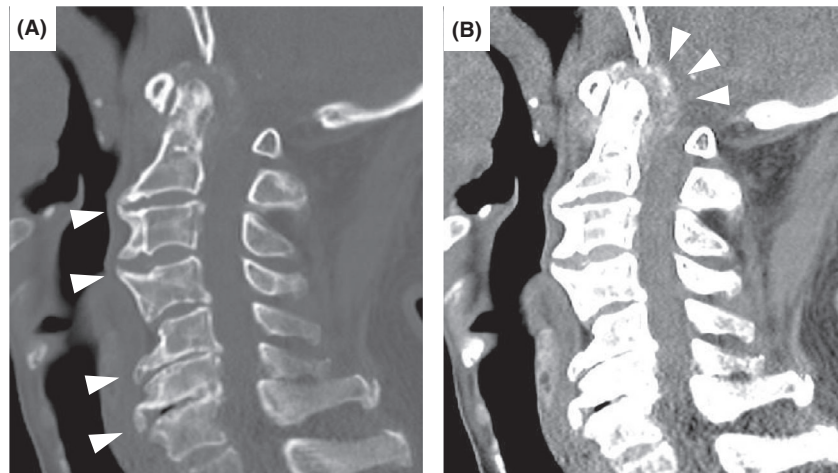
Computed tomography (CT) scan on admission of an 86-year-old man with retro-odontoid pseudotumor. A, The slice showed C2–C7 osteophyte formation (white arrowheads). B, Sagittal slice revealed more obvious high-density area than on (A) (white arrowheads).
